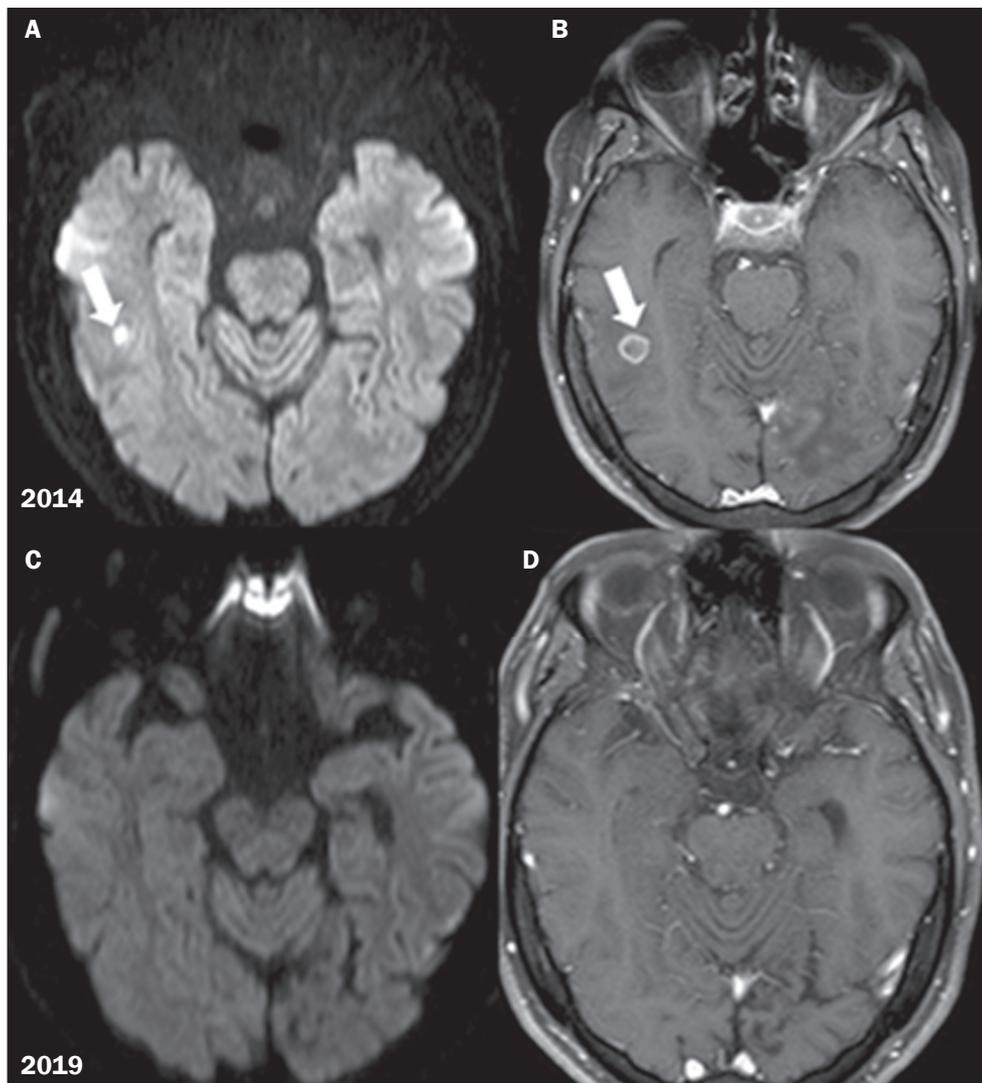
Diffusion-weighted imaging (DWI) analysis. A: Axial DWI showing central restricted diffusion in a small pseudotumor (arrow); B: Axial contrast-enhanced T1-weighted image showing peripheral enhancement (arrow); C,D: Follow-up imaging—axial DWI sequence and contrast-enhanced T1-weighted image, respectively—showing that the lesions had disappeared.
